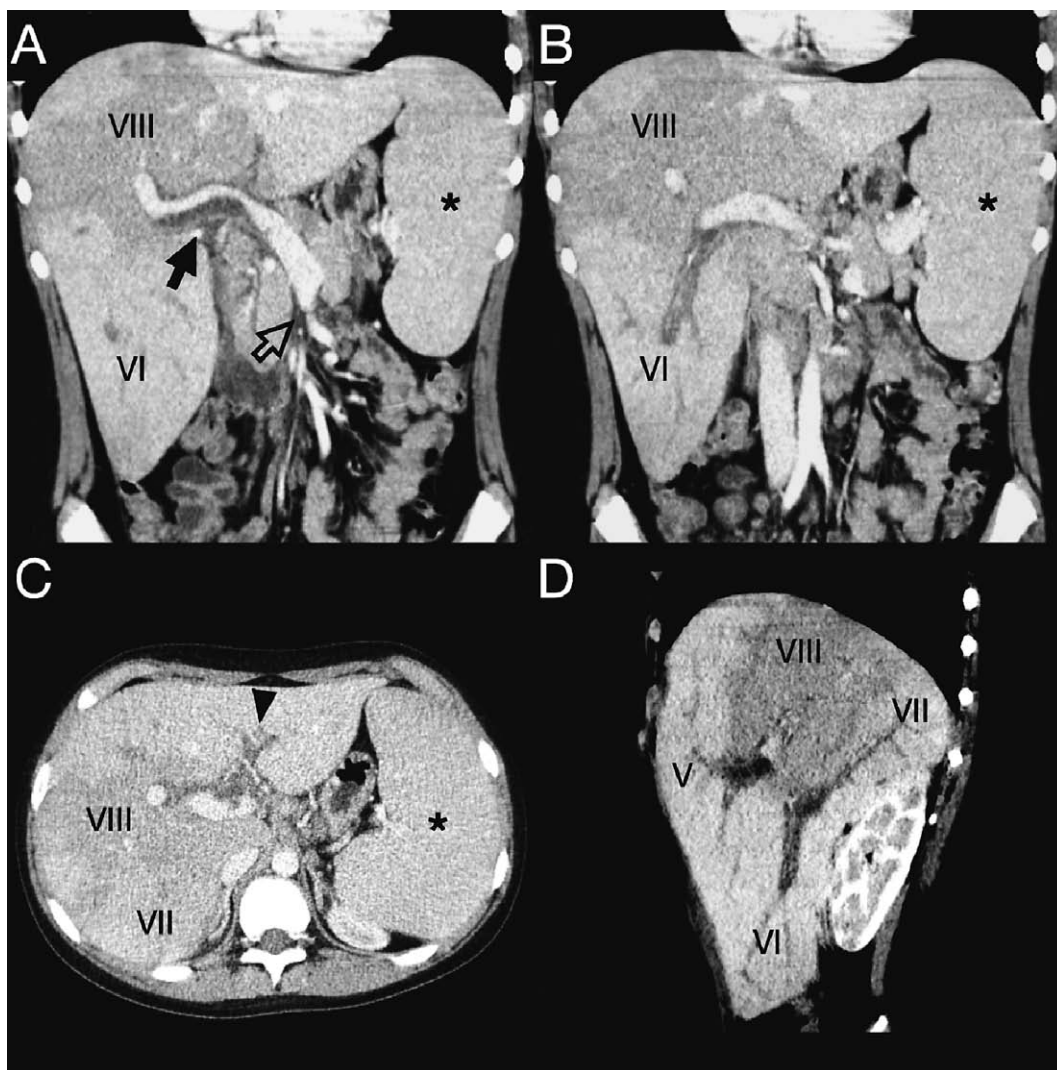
Contrast-enhanced computed tomography in the portal-venous (PV) phase demonstrating enlarged liver, with non-occlusive thrombus in the PV trunk (arrow) and occlusive thrombosis of the left PV (arrowhead) and of the branches of segments V, VI and VII. The parenchyma of the thrombosed segments shows hyperenhancement compared to normal enhancement of segment VIII, due to arterial compensatory flow. Thrombosis of the superior mesenteric vein is also partially seen (arrowhead), as well as splenomegaly (asterisk).
